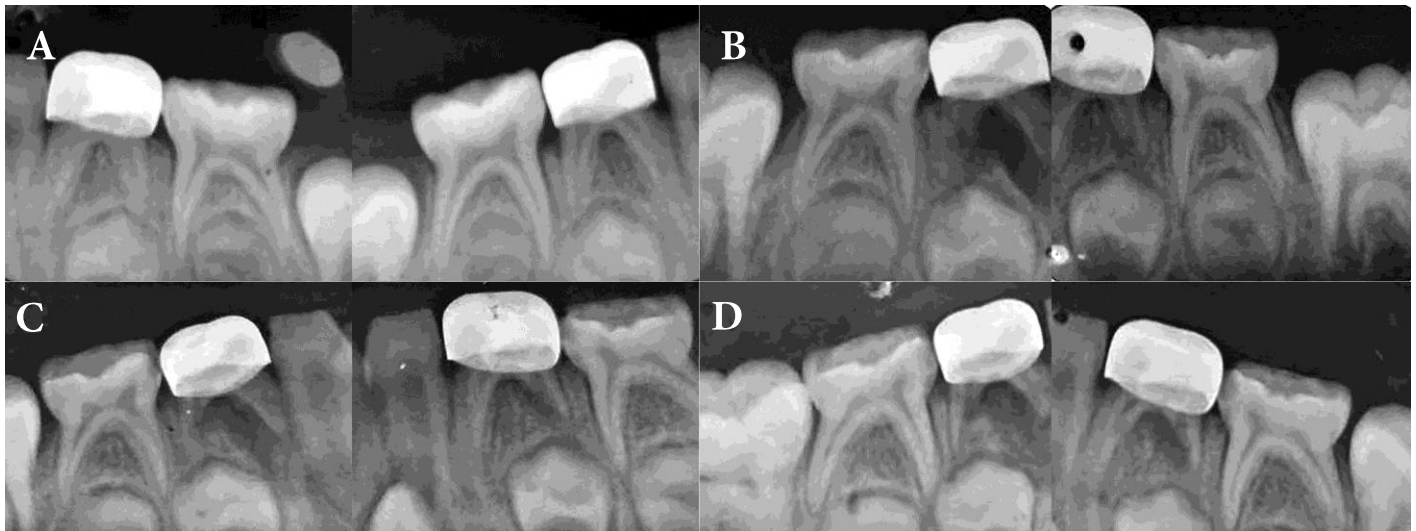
A) Radiographs taken at the end of pulpotomy procedure and restoring with SSC; Right: MTA, Left: propolis; B) Radiographs taken at the 3rd month after treatment; C) Radiographs taken at the 6th month after treatment; D) Radiographs taken at the 9th month after treatment
